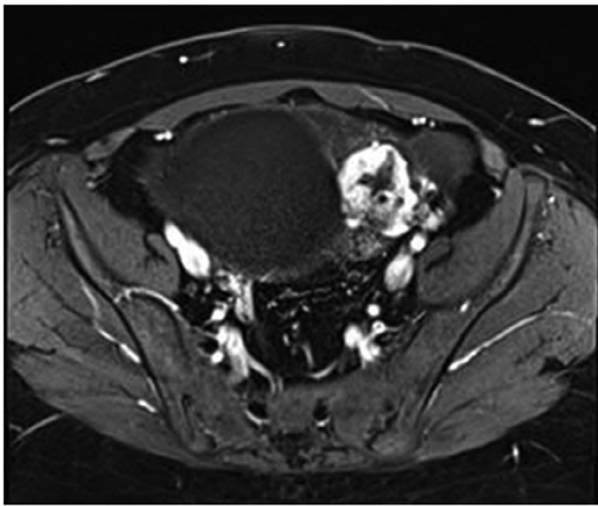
Magnetic resonance imaging of a solid, irregular diffusion restricting heterogeneously enhancing mass in the left adnexa, which measured $4.0 \times 5.6 \times 4.1$ cm
